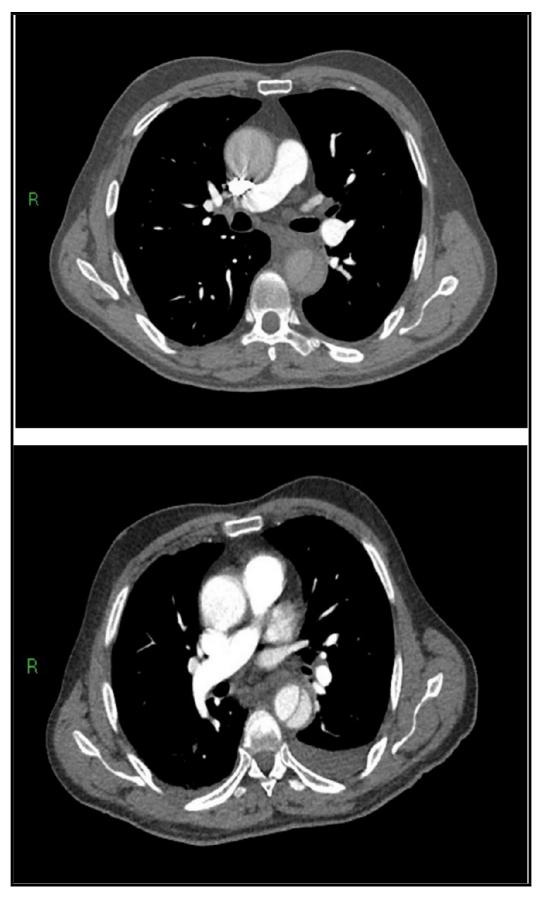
Representative example showing impression of false lumen in descending aorta on CTPA (upper panel) subsequently confirmed as AD by CT aortography (lower panel). CTPA = CT Pulmonary Angiogram. AD = Aortic Dissection.
